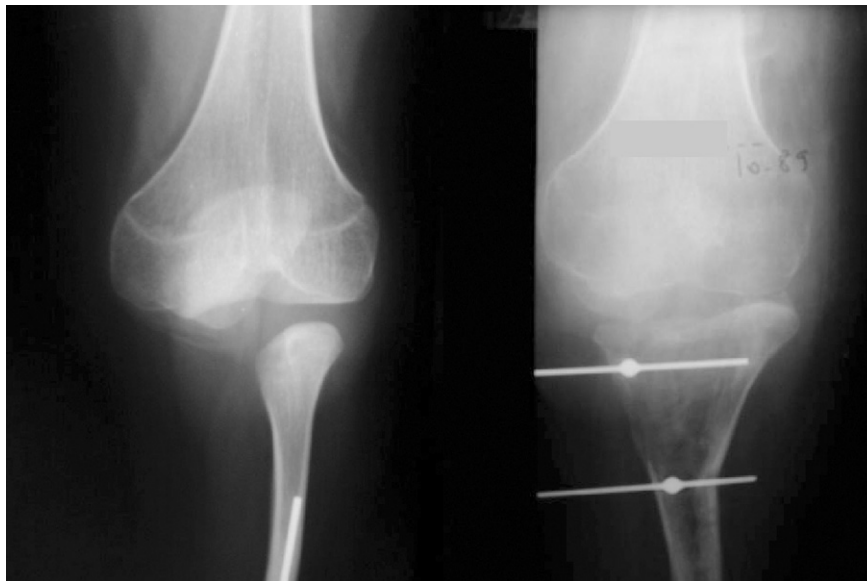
Congenital deficiency of the tibia type 1 (case n° 3). Radiographic aspect (A-P view) of the knee before and after transversal widening of the fibula.
